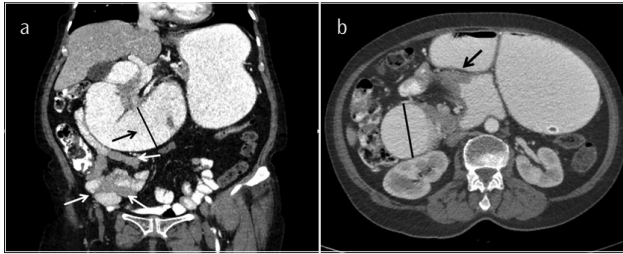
a, b. (a) Malrotation is seen in CT findings. Jejunal segment of the small bowel is located on the right side of the abdomen (white arrows). Duodenal segments are enlarged (black arrow and straight line). (b) Duodenojejunal junction is located on the right side to the mid-line. Arrow shows the duodenojejunal junction tumor. Duodenal segment enlargement due to the obstruction of this lesion is seen on CT (straight line)
